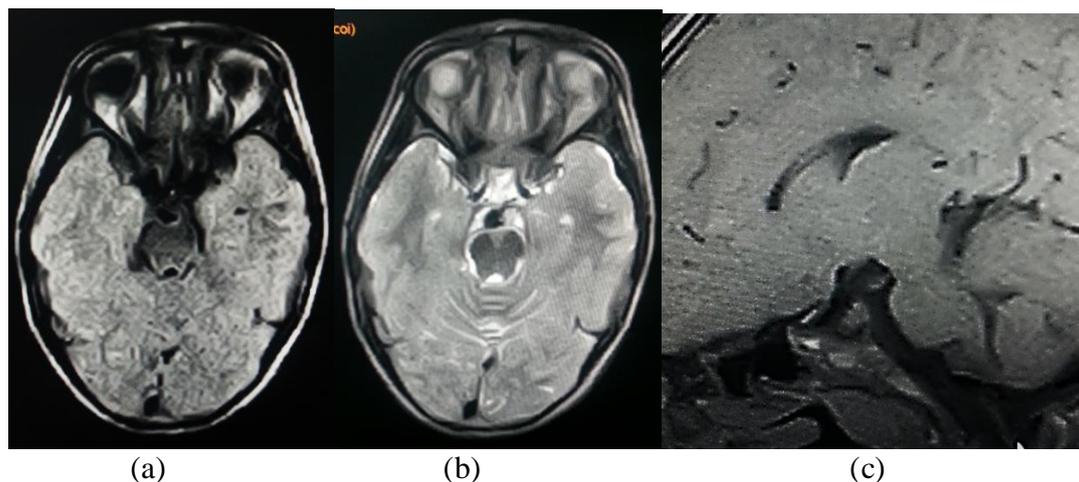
A 6- year- old boy with hyperactivity, impulsive action and inappropriate response. a) Axial FLAIR and b) axial T2WI show a well-defined low signal lesion at the right side of interpeduncular cistern. c) Sagittal T1WI showed markedly thickened tuber cinerium with marginal signal void of calcification (Final diagnosis cavernous hemangioma of tuber cinerium).
